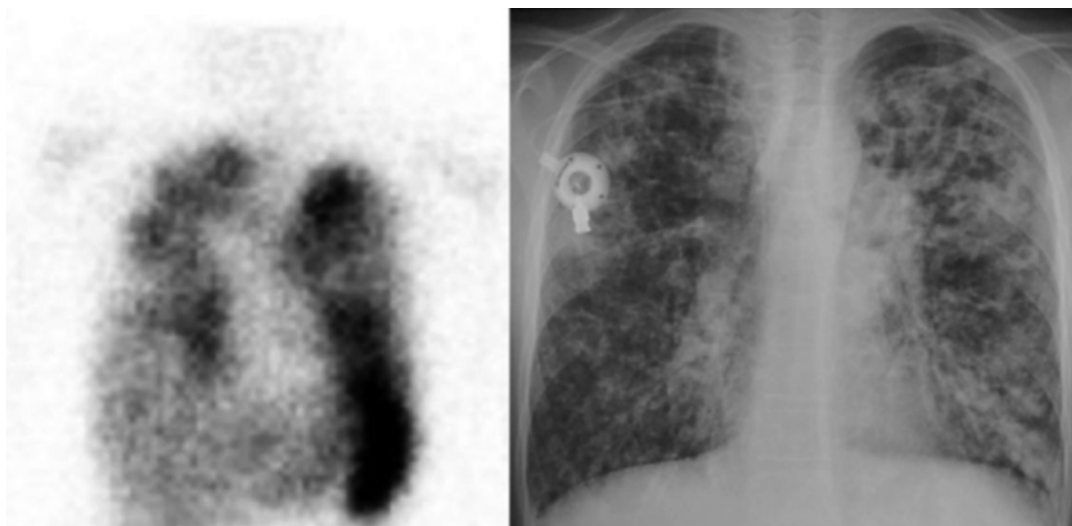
There is intense, multifocal, bilateral pulmonary uptake of ^{111}In -labeled leukocytes (*left*) in a 15-year-old patient with cystic fibrosis. Chest radiograph (*right*), which demonstrates diffuse fibrotic changes with large bronchiectatic cavities and air space infiltrates, was
